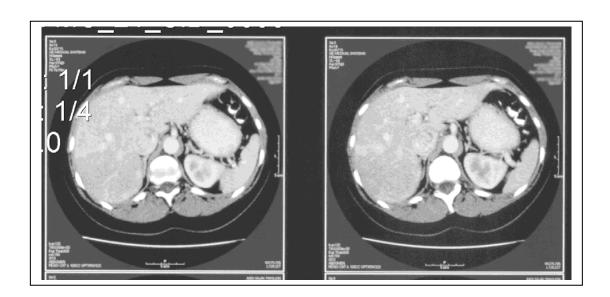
7 months after initial CT and with continued symptoms, abdominal CT showing new biloma.
